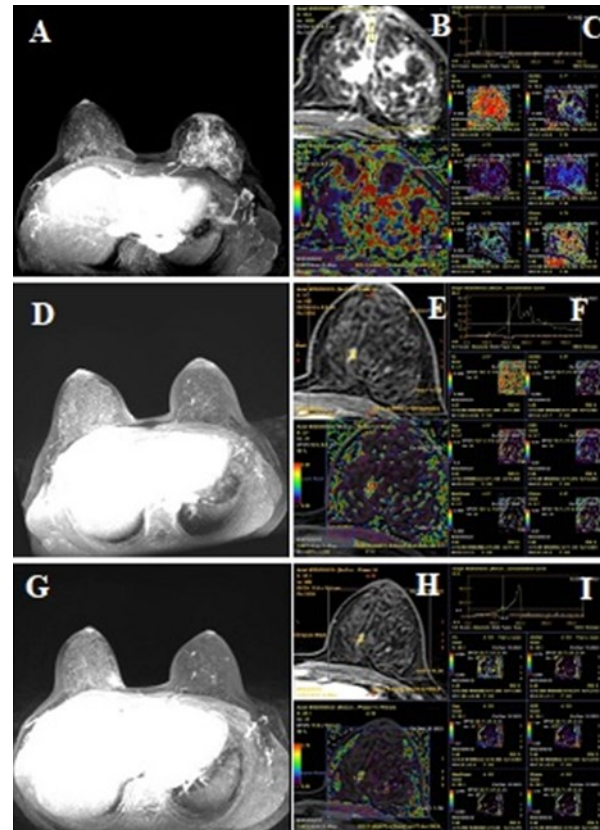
DCE-MRI images of patients with effective breast cancer treatment. 1A-1C: T1WI enhanced images and MRI quantitative parameters before NAC treatment; 1D-1F: T1WI enhanced images and MRI quantitative parameters after the first NAC treatment; 1G-1I: T1WI enhanced images and MRI quantitative parameters after the last NAC treatment.
